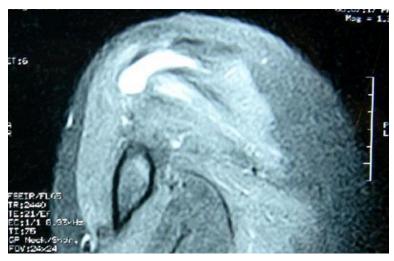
MRI image showing glenohumeral joint effusion
